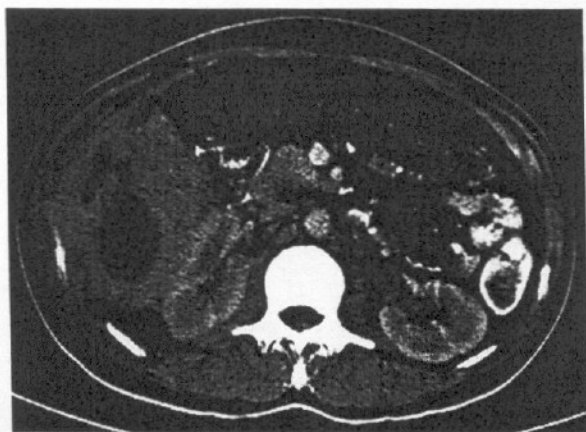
Contrast-enhanced CT of the abdomen showing the liver with three coalescing abscesses.
